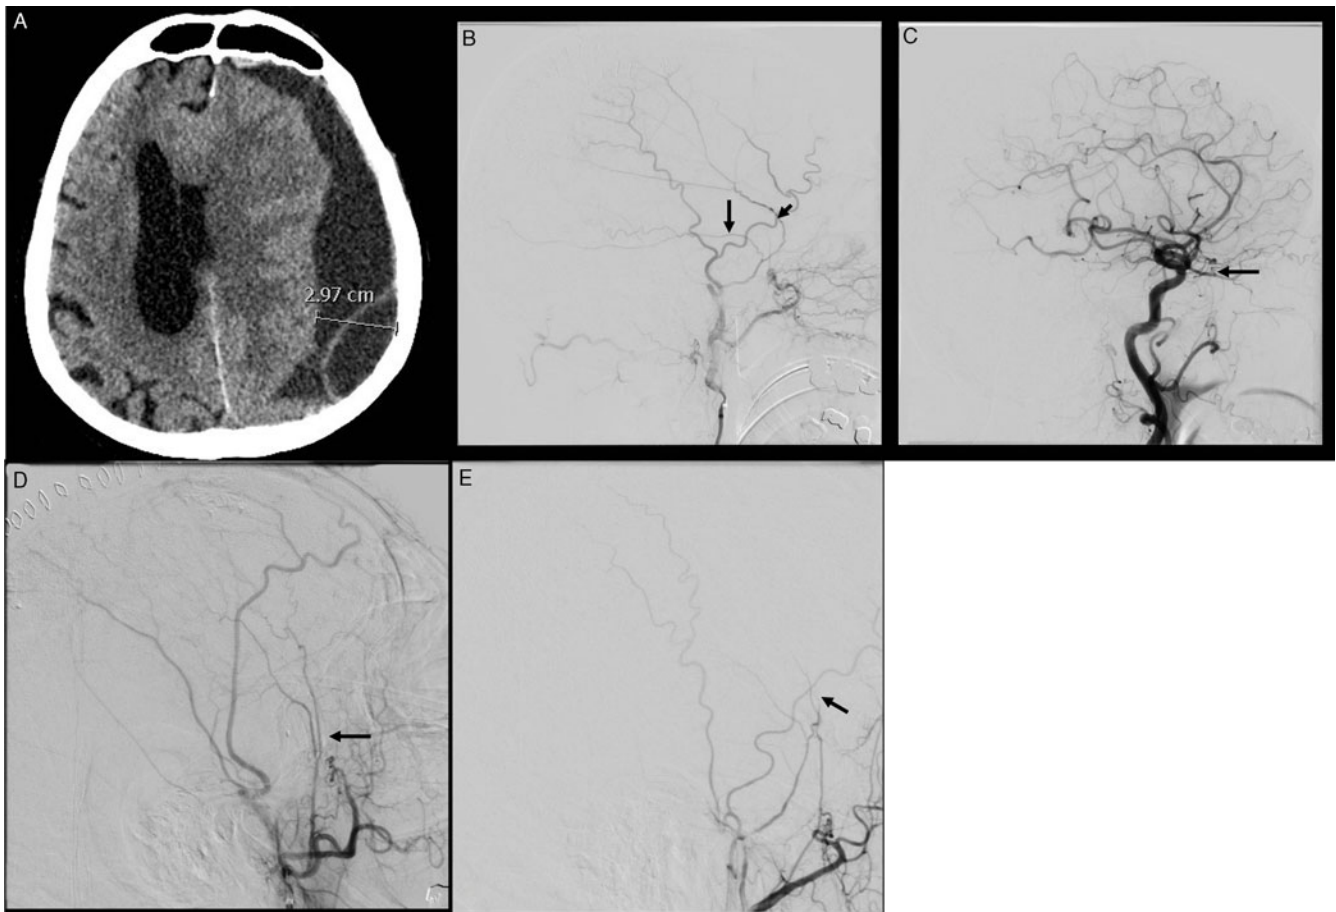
Chronic subdural hematoma on CT head (a). External carotid artery (ECA) angiogram showing classic anterior and posterior divisions (arrows) of the middle meningeal artery (MMA) (b). (c) Common carotid angiogram showed MMA arising from the ophthalmic artery and EMMA could not be achieved (grade 0). (d) Post-EMMA, ECA angiogram shows continued filling of the anterior division territory of MMA by the ipsilateral accessory meningeal artery (arrow) filling 50% of the MMA territory (grade 1). (e) Post-EMMA, ECA angiogram shows embolization of most of MMA territory except small filling (arrow) of the anterior division (grade 2). (f) Post-embolization of the middle meningeal artery (EMMA), there is no residual filling of the MMA territory (grade 3).
